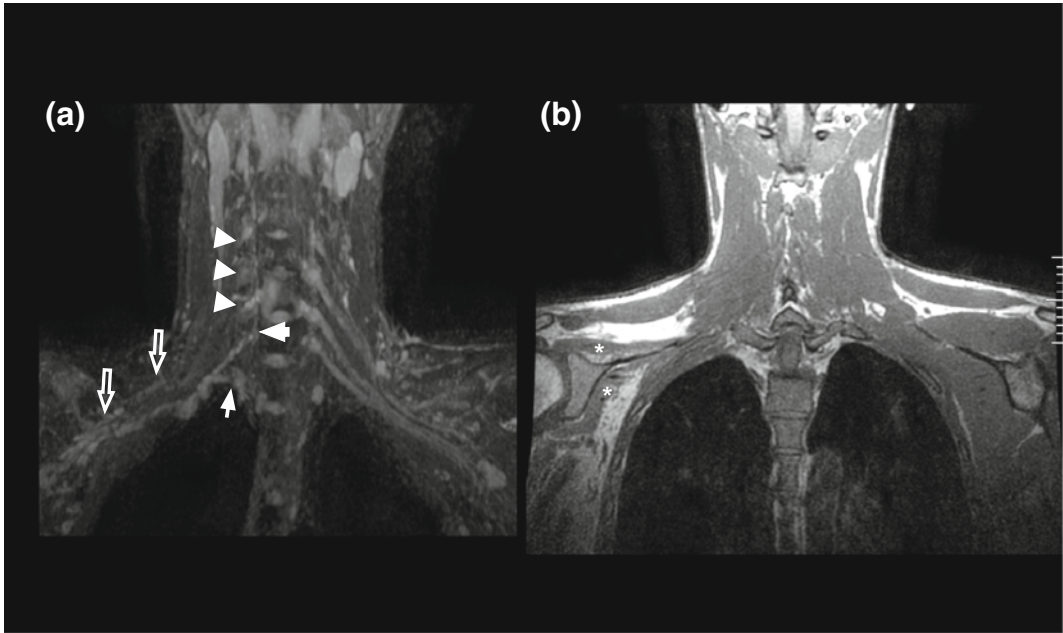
Traumatic postganglionic injury: brachial MR neurography exam was obtained 6 months after motor vehicle crashes in a 25 years old man. Sequence 3D IDEAL coronal T2-weighted images (a), shows postganglionic injury of C5 to T1 roots, with nerve discontinuity
